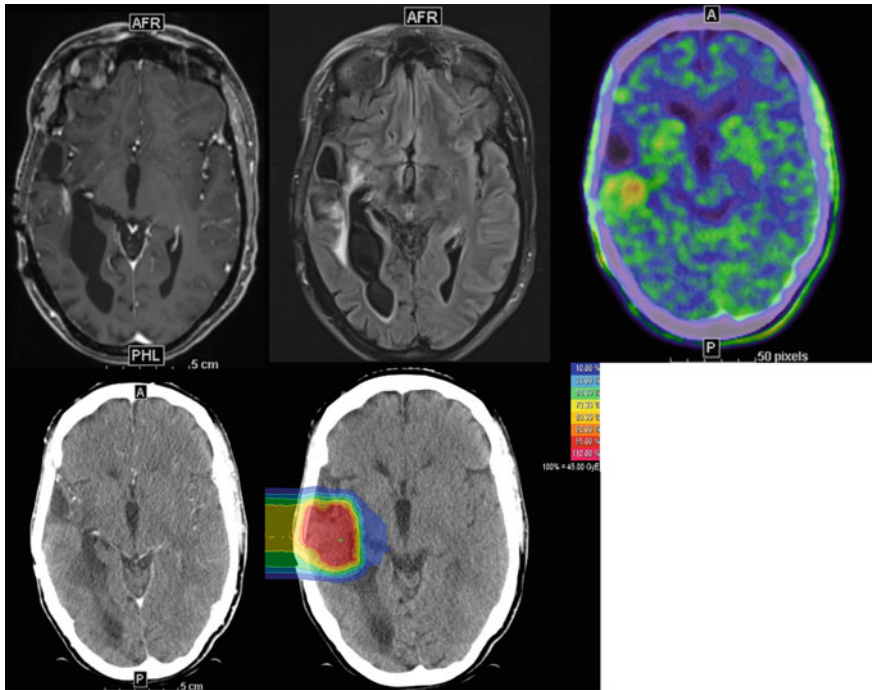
Combining morphological and functional imaging for particle treatment planning: 38-year-old female patient with a history of astrocytoma WHO ^\circ II of 9 years. As the patient was pretreated by surgery and photon radiotherapy, different modalities were used to identify vital tumor and differentiate from treatment-associated changes: (upper row, from left to right) CM-enhanced T1-MPRAGE MRI sequence, T2-FLAIR MRI sequence, FET-PET/CT, and (lower row, left) CM-enhanced CT. Dose distribution of the according treatment plan (lower row, right), re-irradiation was performed with carbon ions, total dose 51 Gy (RBE), single dose 3 Gy(RBE), 17 fractions
